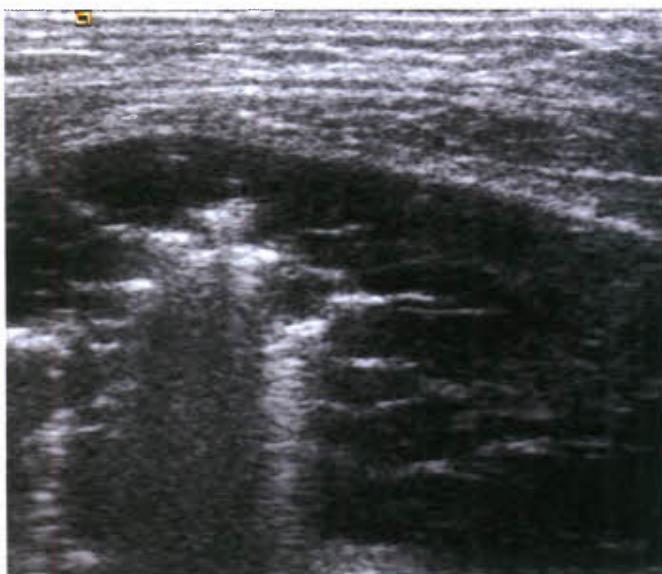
Sclerotherapy of VMs with sodium tetradecyl sulfate foam. Ultrasonography reliably differentiates between the portion of the VMs injected with the foam (hyperechoic signal with air artefact) and the untreated portions.
